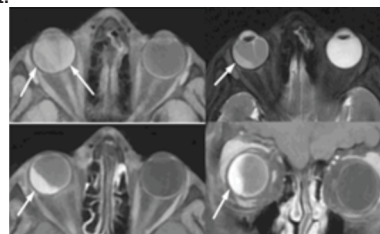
MRI showing crescentic shaped lesion in the temporal aspect along choroidal layer of right eye and subretinal hemorrhage within the globe
